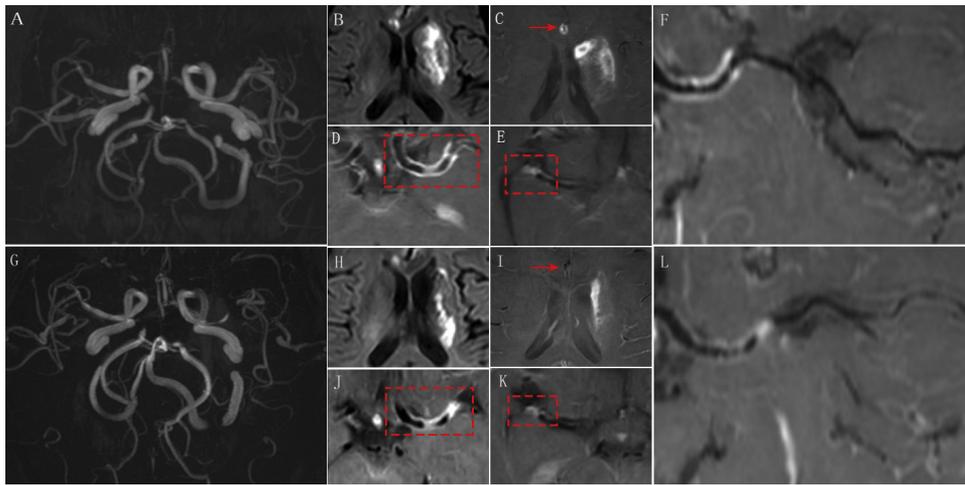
The case was clinically confirmed syphilitic vasculitis via cerebrospinal fluid examination and serologic test. MRA showed slightly stenosis of bilateral ACA (anterior cerebral artery) and MCA, but not apparently (A). DWI showed the left basal ganglia had acute cerebral infarction (B). 3D VW-MRI after contrast showed uniform thickness and vivid enhancement of the right ACA, the M1 segment of left MCA, the right MCA bifurcate vessel wall (C, D, E, and F). And for the images acquired during follow-ups (after 6 months), due to the patient refused treatment after discharge, the stenosis of left MCA was progressed significantly (G), the left basal ganglia presented with a new acute cerebral infarction (H), and the left MCA had a new localized stenosis and enhancement (J, L), but the enhancement intensity had been apparently declined (I, J, K, and L). F and L showed left MCA obtained by curved planar reformation. Abbreviations: DWI, diffusion-weighted imaging; MCA, middle cerebral artery; MRA, magnetic resonance angiography; VW-MRI, Vessel Wall-magnetic resonance imaging. (Color version of figure is available online.)
